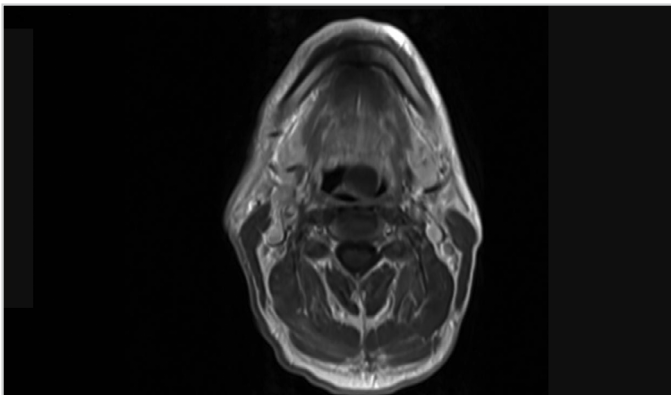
In the section of post-contrast axial T1-weighted MRI, a mass originating from the left margin of the epiglottis is observed
